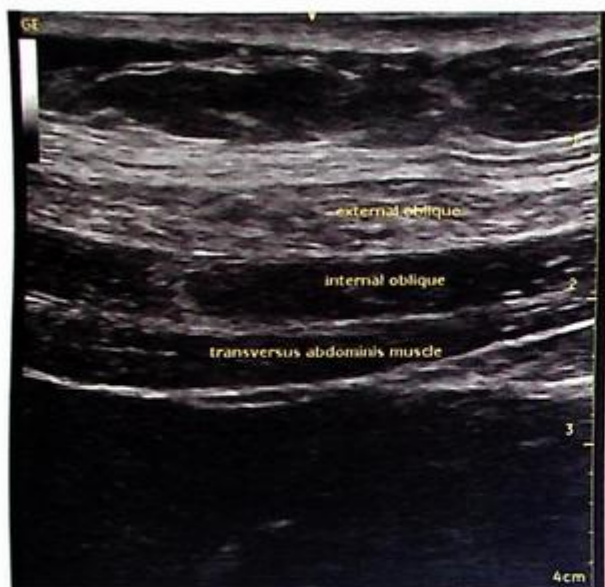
Ultrasound still of the anatomy of the transversus abdominis plane block.
